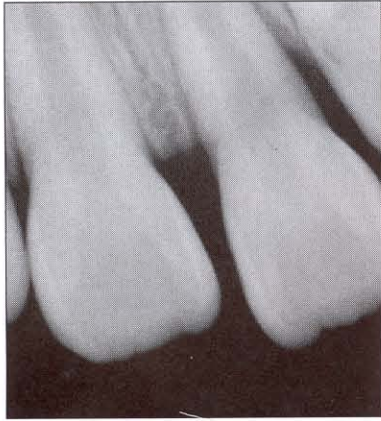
A radiograph of a partially avulsed central incisor.
